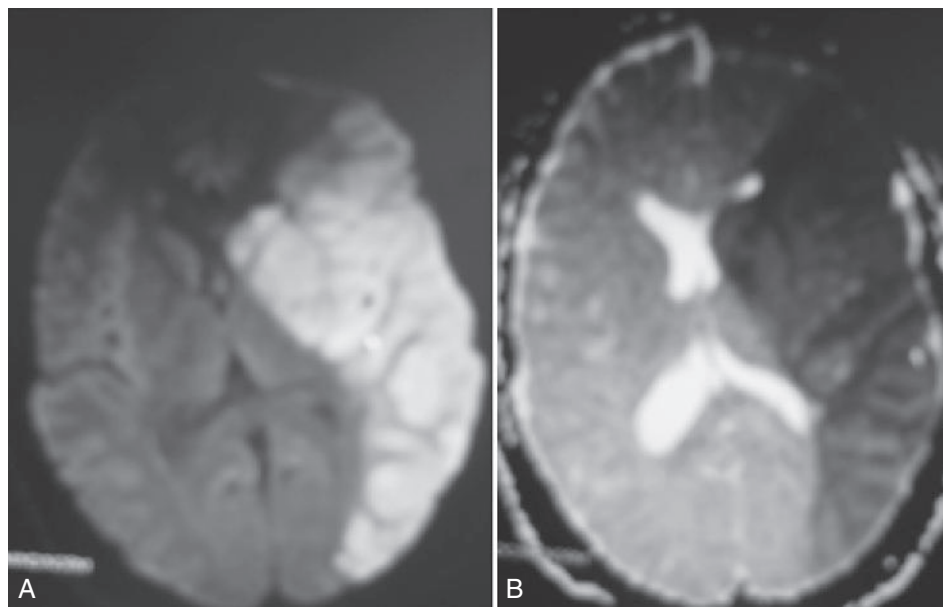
Magnetic resonance imaging scan of the brain of the same patient shown in Figure 116-4. A, Diffusion-weighted image shows bright signal in the left middle cerebral artery territory. B, Apparent diffusion coefficient shows dark signal in the same area, confirming acute infarction.
